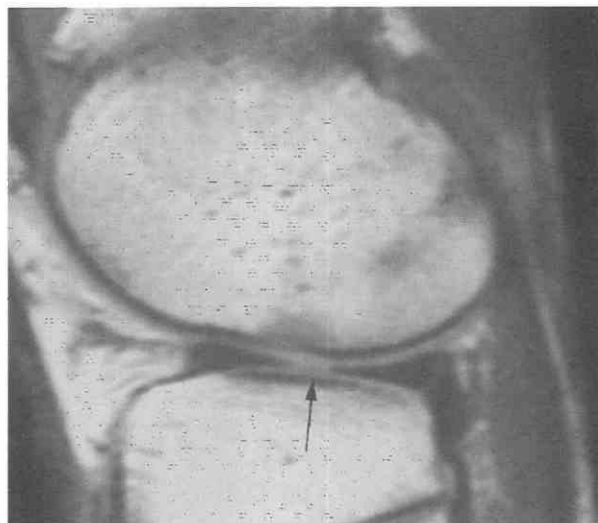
Parrot beak tear. Sagittal T1-weighted image shows increased signal intensity interrupting the "bowtie" configuration of the lateral meniscus (arrow) indicative of a parrot beak tear.
